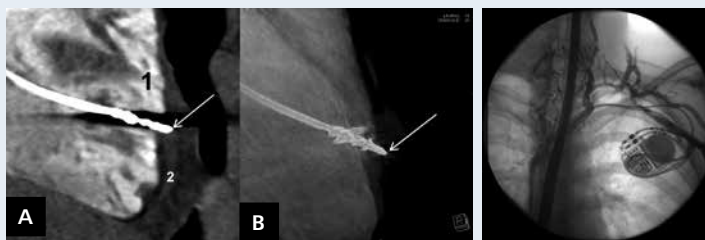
CT (arrow) perforating lead tip; A. Multiplanar reconstruction; 1 — right heart cavity with contrast medium; 2 — pericardial sac space; B. Volume rendering technique
